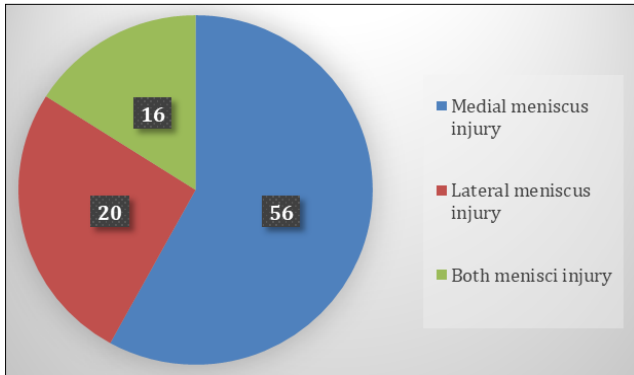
Number of patients with meniscus injury on MRI (N=92)
